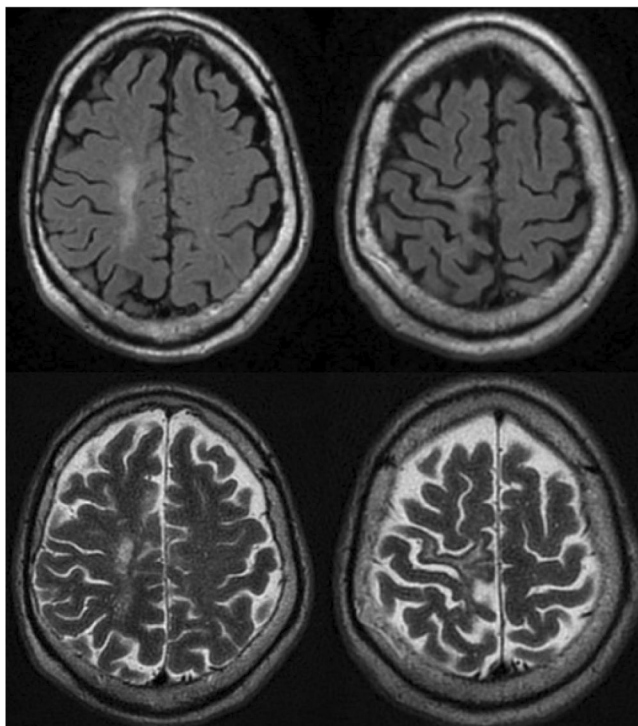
Axial FLAIR and T2-weighted MRI after maraviroc treatment.
